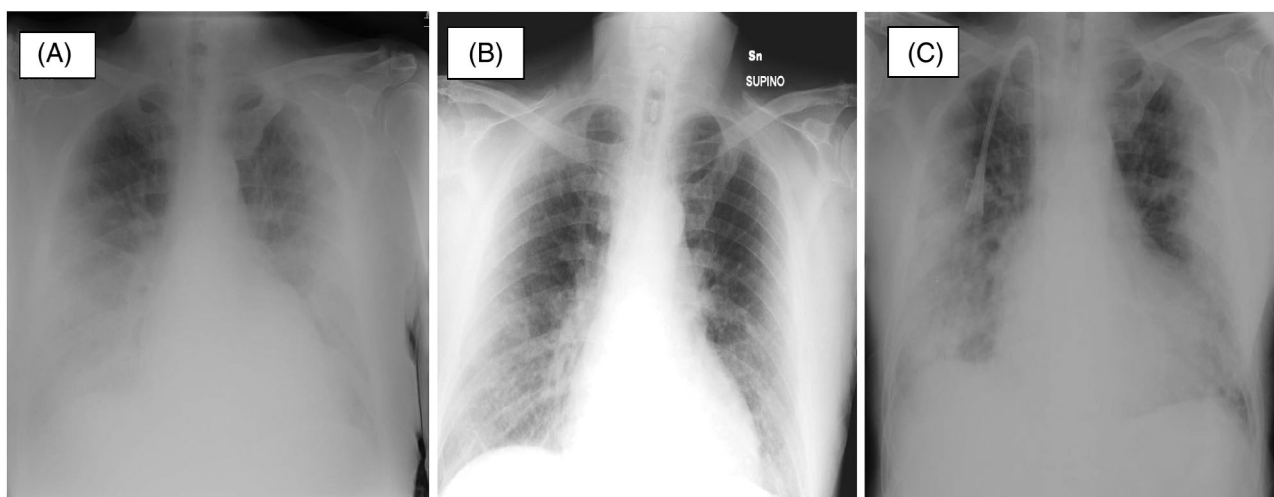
Chest x-ray. (A) Extensive bilateral airspaces disease and cardiomegaly. (B) Partial reduction of lung vascular congestion and bilateral pleural effusion; detection of ground-glass opacities in both basal fields. (C) Detection of consolidative opacities in both lung fields.
